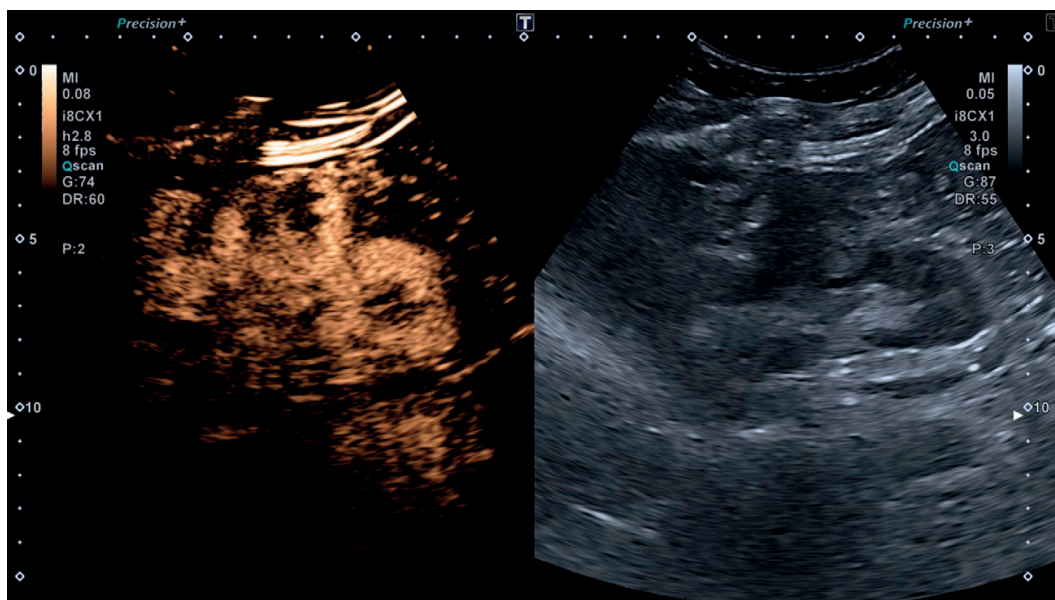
(a and b) Angiomyolipoma. CEUS (left) and gray scale ultrasonography (right). There is a tumor, round, well defined, and hypoechoic, with peripheral vascularity. The aspect suggests the presence of a neoplasia, but is not entirely typical for angiomyolipoma.
